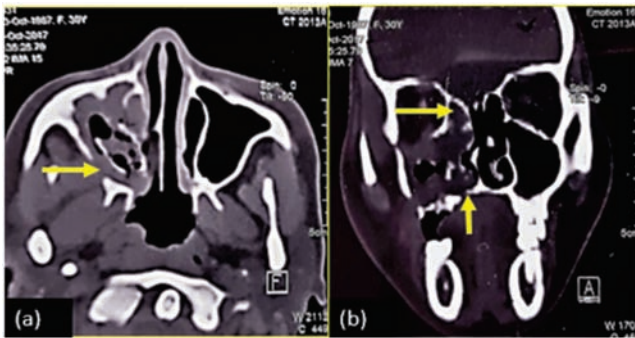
a) CT axial section showing hypodense mass with erosions in right maxillary sinus
